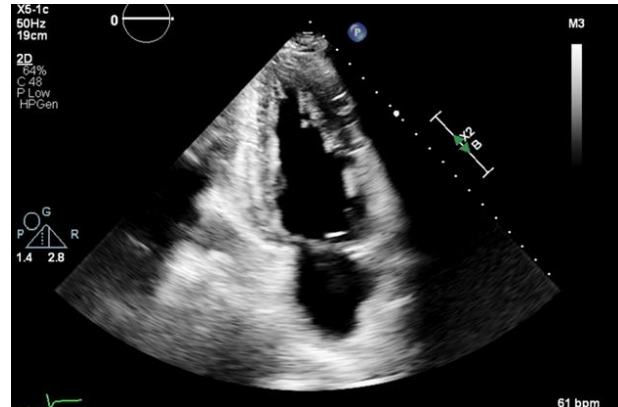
(A and B) Apical 4-Chamber View and 2-Chamber View:
